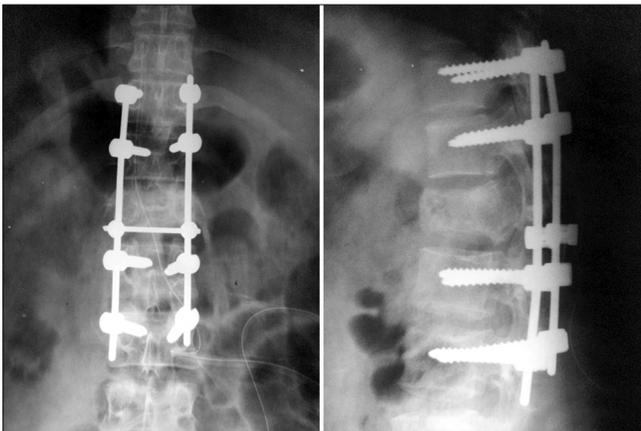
Postoperative X-ray showing long-segment fixation without instrumentation of index vertebra of L1 vertebra fracture.
